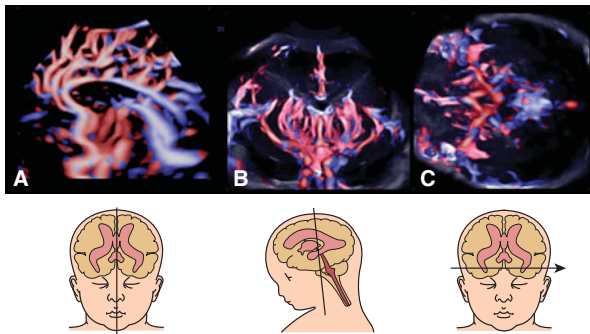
Reconstructed 3D angiography of normal cerebral circulation at 31 postmenstrual weeks. 3D bidirectional power Doppler angiograms of sagittal (A), coronal (B), and axial (C) sections.
